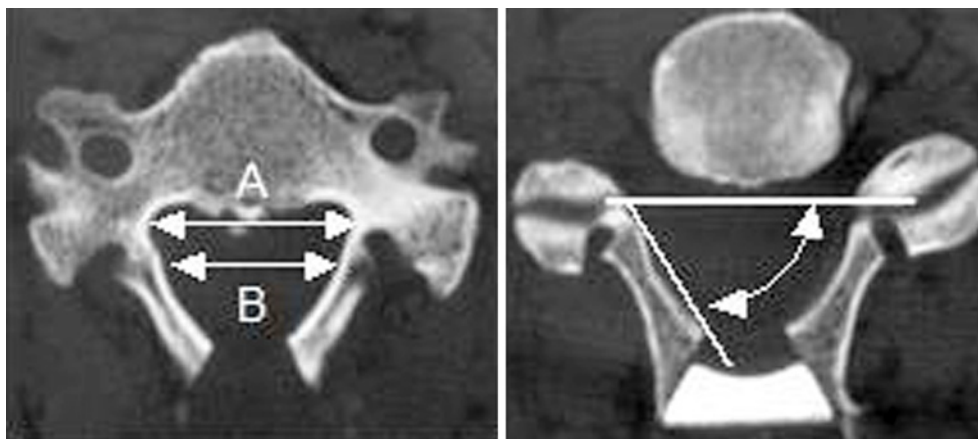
Widths between the bilateral gutters (left) and the inclination angles of the lamina (right) measured on axial computed tomography images. (A) Transverse diameter of the spinal canal; (B) distance (inside) between bilateral gutters.
